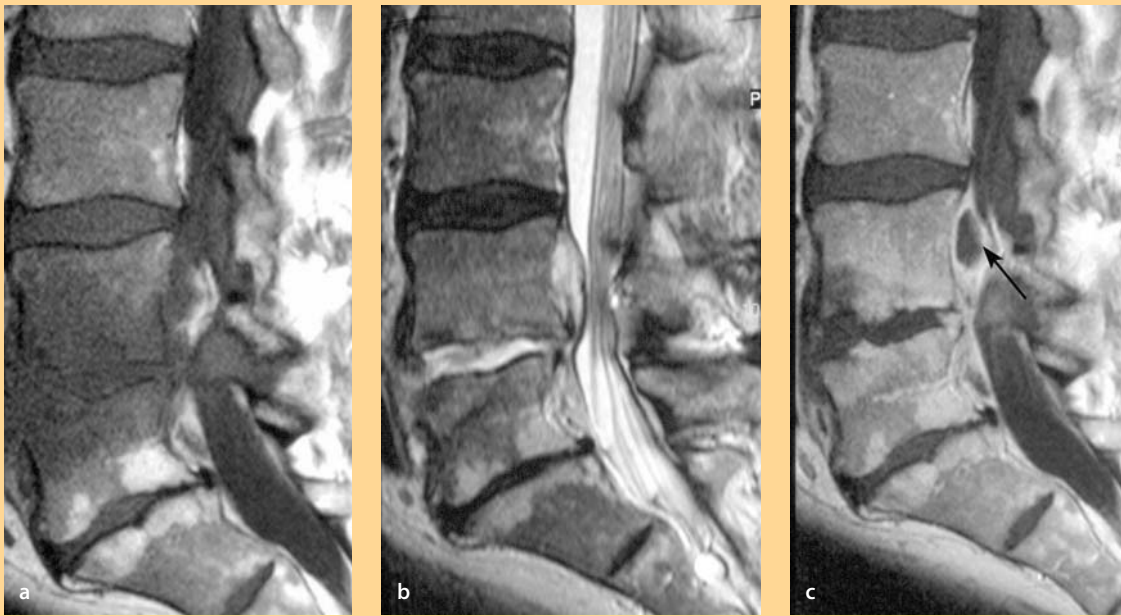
MRI characteristics of spinal infections
